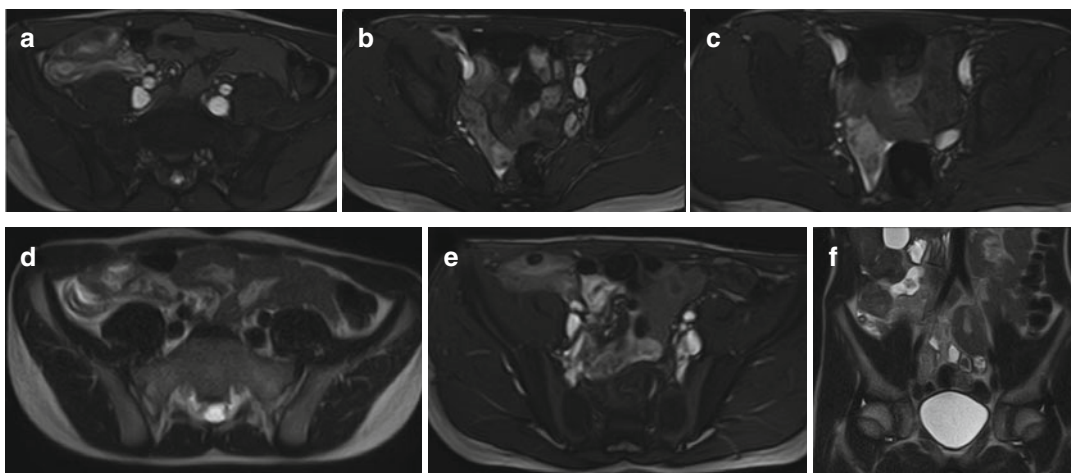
(a–f) MRI with gadolinium: the appendiceal walls were isointense on T2-weighted images. The normal appendix was the visualization of a blinded tubular structure that extended from the cecum and had a transverse
